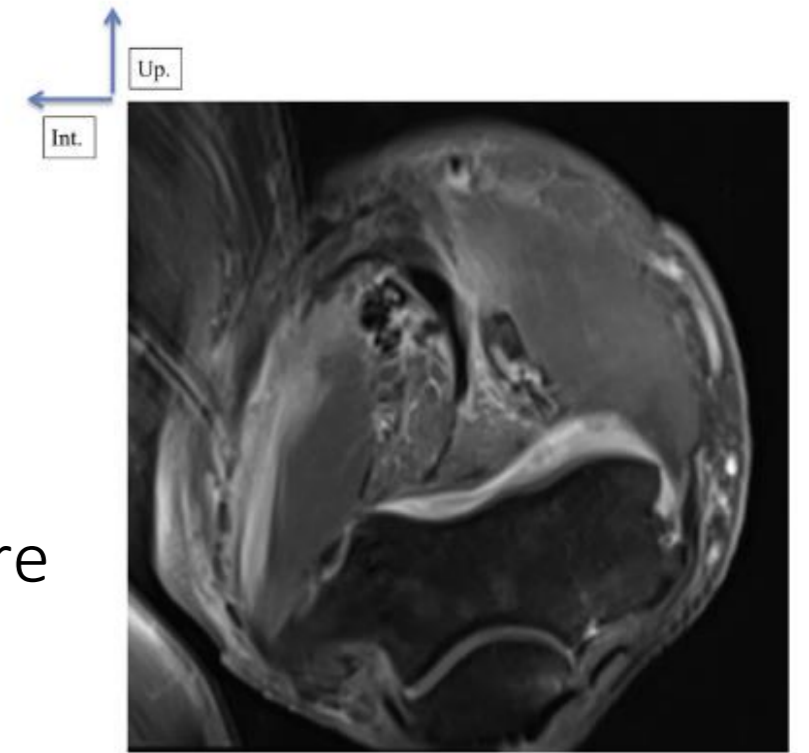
Left upper arm on MRI (T1 + Gadolinium-weighted): soft tissue infiltration, muscular inflammation and muscle signal abnormality (pronator teres, brachioradialis muscle, and brachialis muscle).
